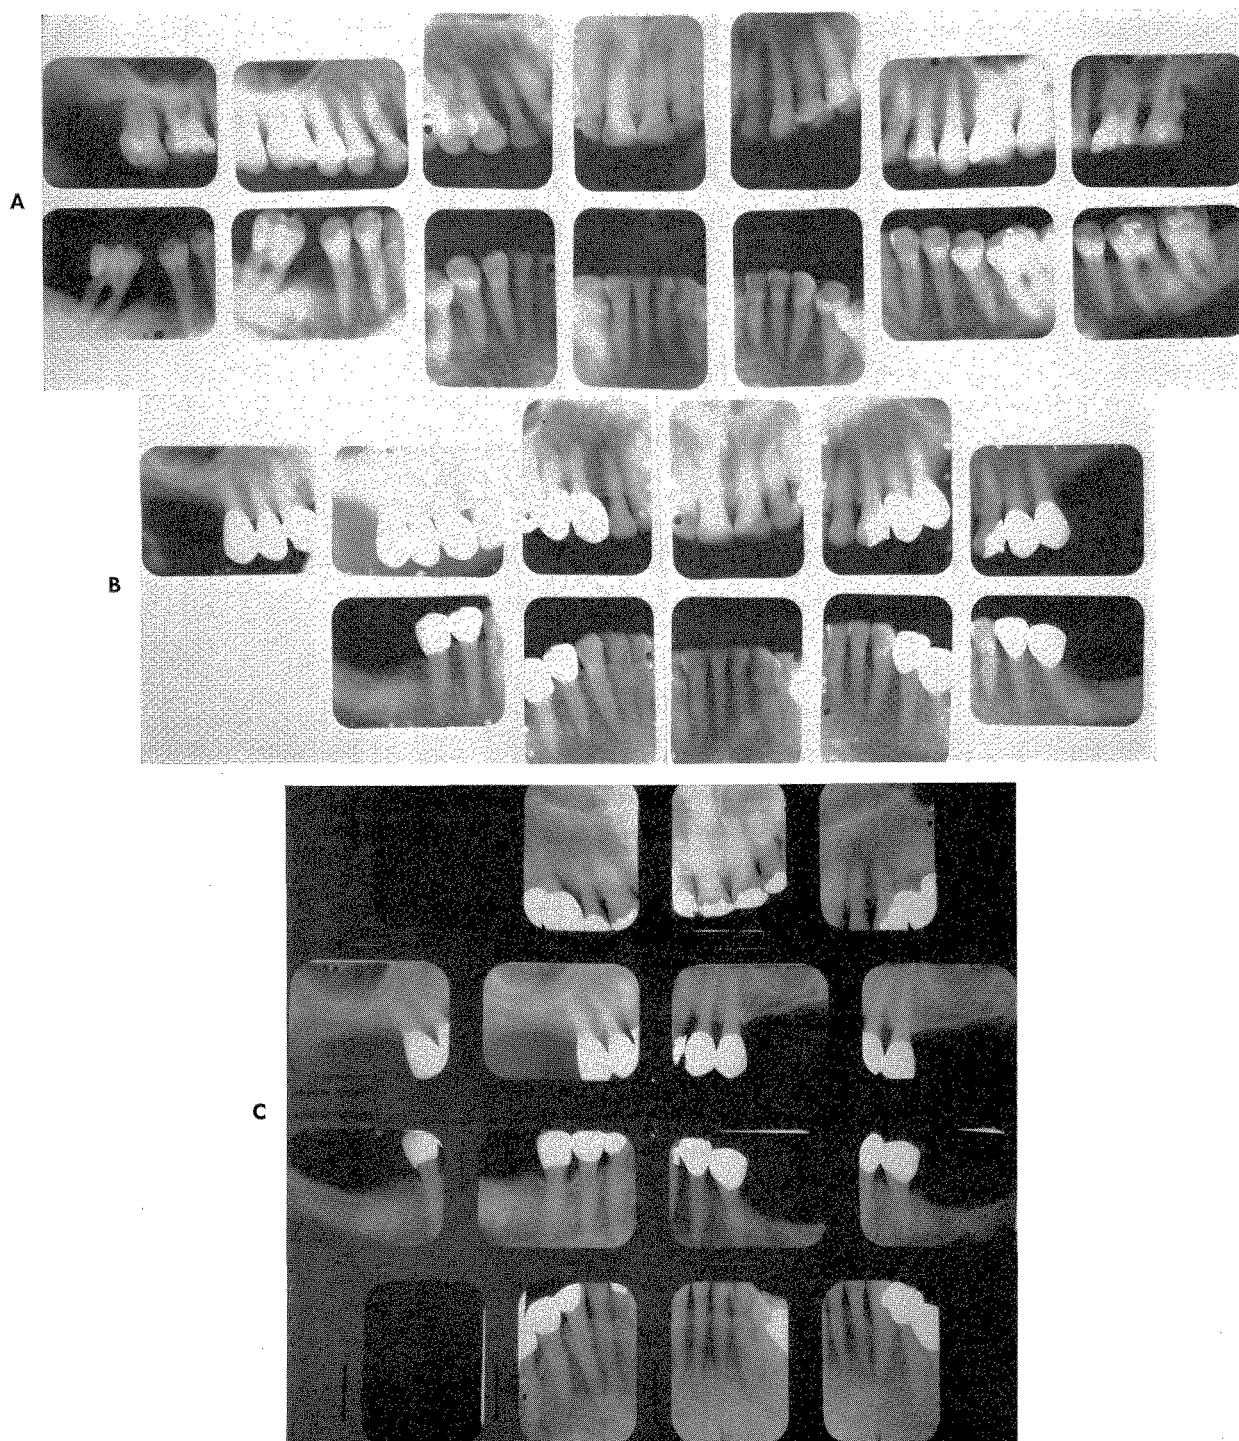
Roentgenograms of the case shown in Fig. 343 taken in 1948, A; in 1950, B; and in 1962, eleven years after completion, C. This is another case similar to the one shown in Figs. 244 to 248 in which the periodontal disease was checked.
